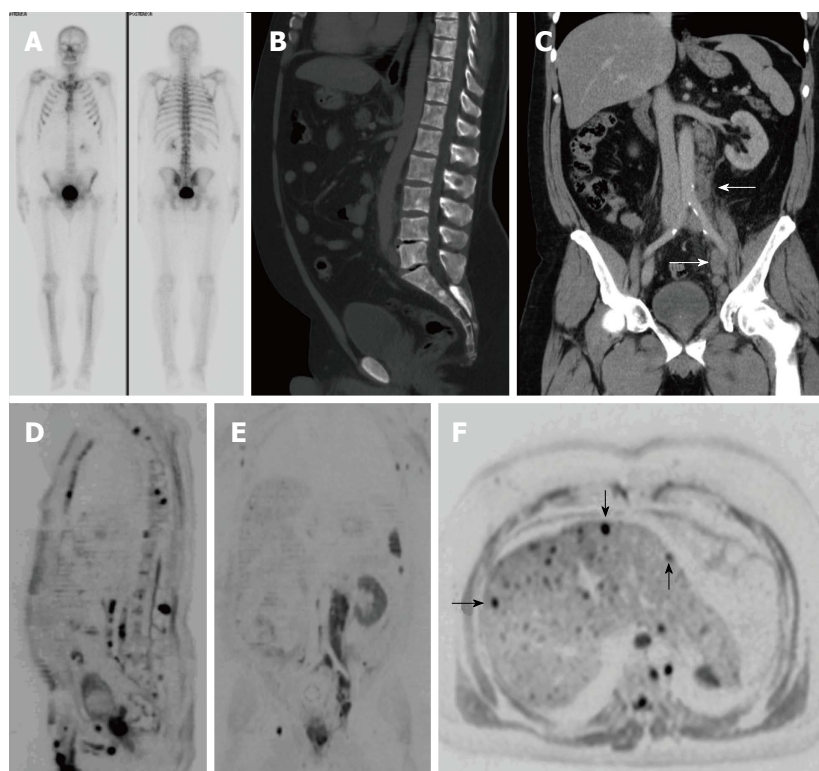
A 51-year-old patient with a history of Gleason 4 + 5 prostate carcinoma treated with hormone therapy. A: Re-staging bone scintigraphy was negative for bone metastases; B and C: Sagittal (B) and coronal (C) images of abdominal CT scan show a diffuse axial bone altered density that could not rule out bone metastases, along with multiple retroperitoneal and pelvic enlarged nodes suggesting malignant adenopathies (white arrows in C); D and E: Sagittal (D) and coronal (E) whole-body MRI images clearly show multiple bone metastases and adenopathies, along with hepatic nodules (black arrows in F, axial abdominal MRI) suspicious for metastatic disease. MRI: Magnetic resonance imaging.
